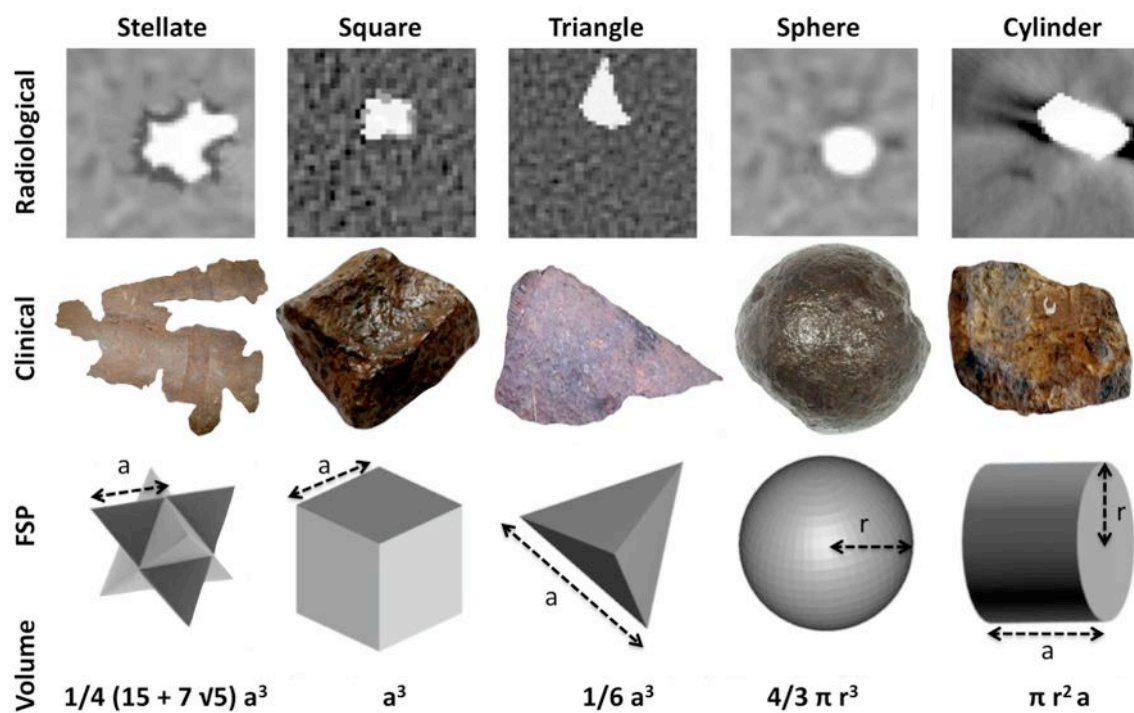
Clinical, radiographic, and mathematical appearances of FSPs including volume calculations.
